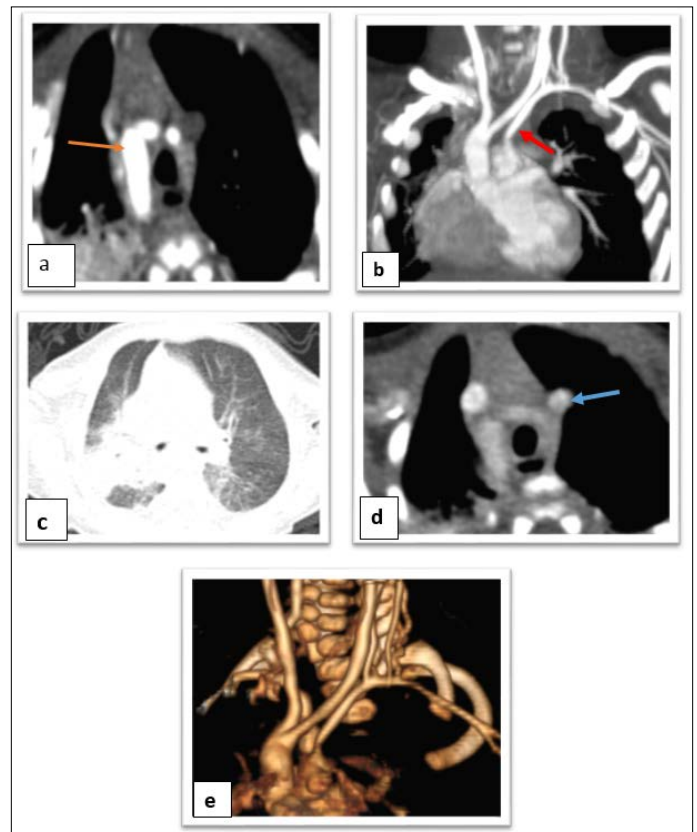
Computed tomography (CT) :a: right aortic arch(orange arrow); b: isolated left subclavian artery communicating with the trunk of the pulmonary artery via a patent ductus arteriosus(red arrow); c: right pulmonary condensation on parenchymatous window; d: persistence of the left superior vena cava(blue arrow); e: 3D reconstruction
